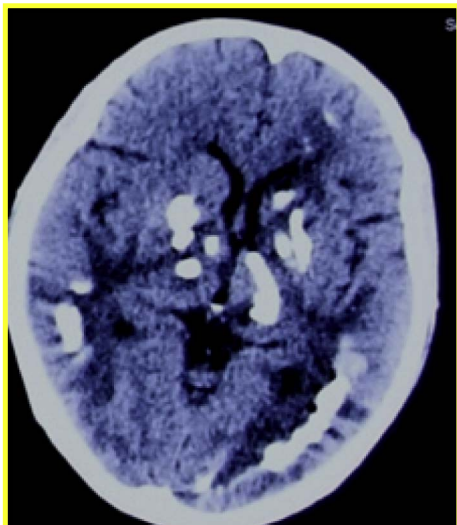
Cranial CT scans showing variable and asymmetrically distributed calcifications in the deep cortex and basal ganglia.
